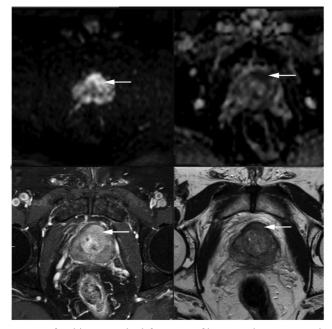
A focal lesion in the left anterior fibromuscular stroma with extension into the adjacent central zone showing marked diffusion restriction appearing hyperintense on DWI, hypointense on ADC map showing early enhancement on DCEI and well-defined T2 hypointensity (arrows) s/o PIRAD 5 lesion highly suspicious of malignancy.
